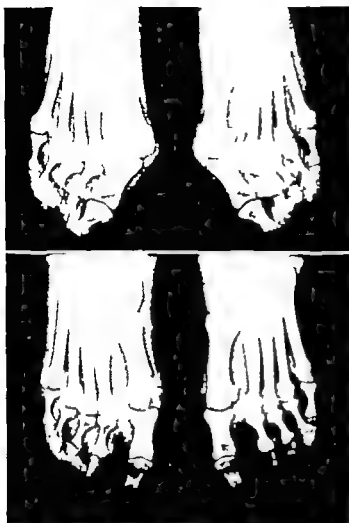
Case No. 6—Mrs. L.M. Multiple Chronic Postural Neuralgias and Foot Deformities. A (Upper) Antero-posterior radiograph showing multiple shoe deformities—adducted Hallux Valgi (bunions) and bunions. B (Lower) Antero-posterior radiograph—six months post operative—corrected position maintained.
